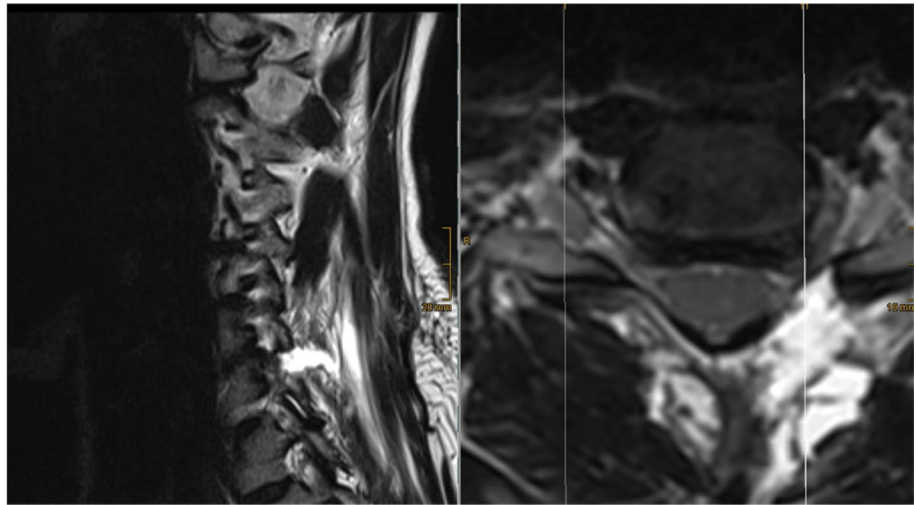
Cervical MRI on initial presentation with left-sided C7 foraminal stenosis
